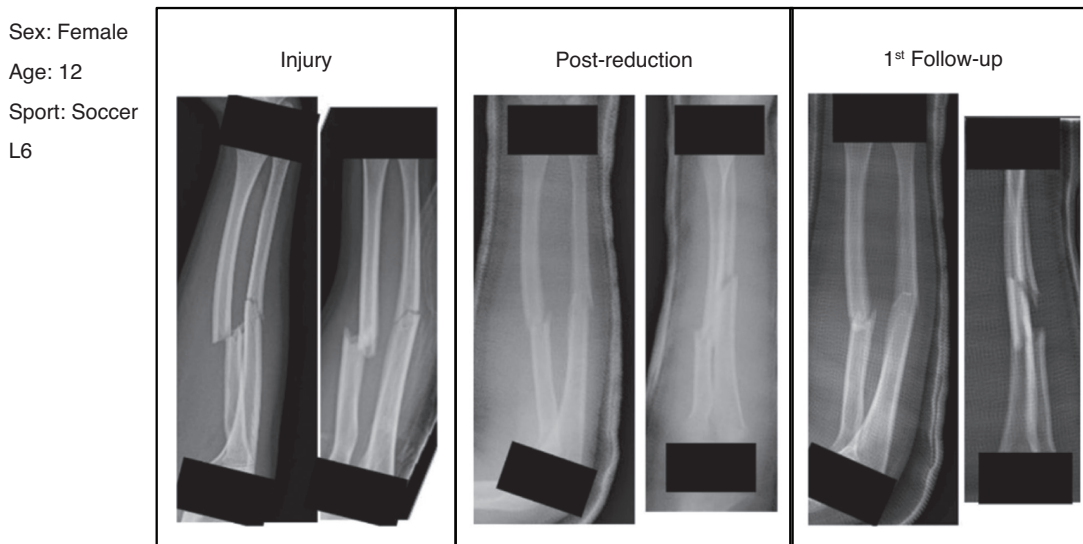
Example slide showing patient specific characteristics in top left with three sets of radiographs obtained at different time points.
